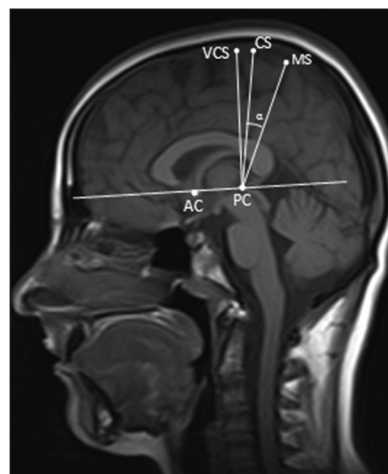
VCS-PC, CS-PC, MS-PC distances, and angle α in mid-sagittal brain MR images. PC: *Commissura posterior* VCS: The distances between cerebral cortex point vertical to *commissura anterior- commissura posterior* line CS: *Sulcus centralis* MS: *Sulcus marginalis* α : The angle between CS-PC-MS
